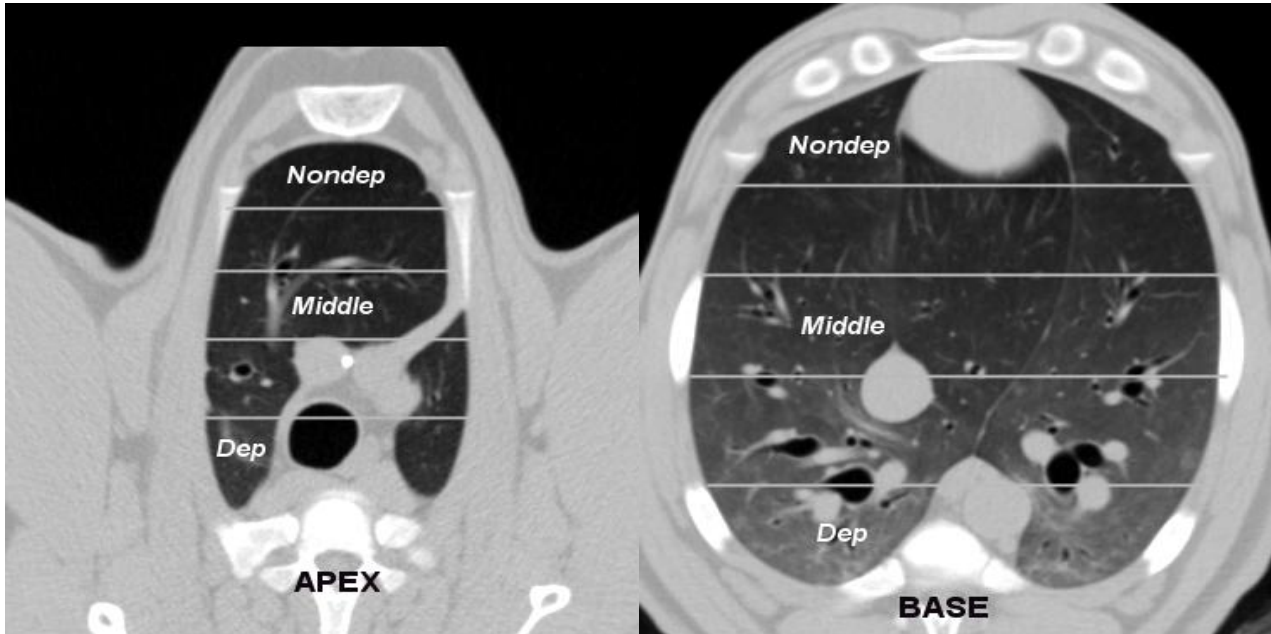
Definitions for the three regions at apex and base for the analysis of difference of washin and washout rate. Transverse CT images at apex/base are divided into 5 regions. The most upper part was used as nondependent region, middle part as middle region, and the lowest part as dependent region.
